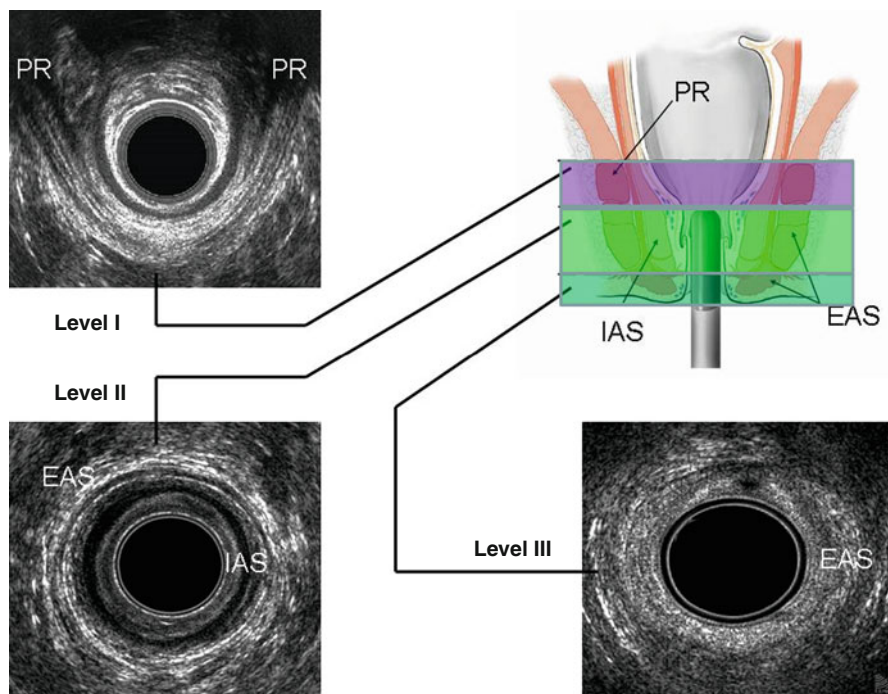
Three levels of assessment of the anal canal by using 3D endoanal ultrasound (see text)
